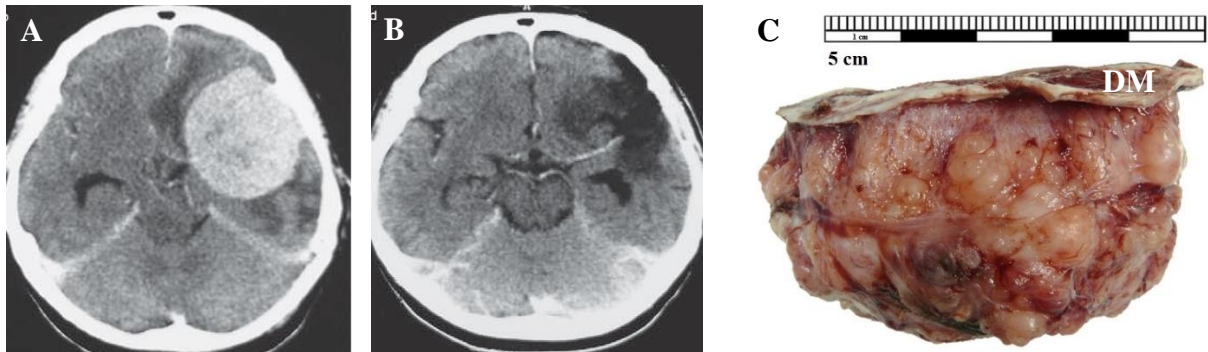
Pre-operative (A) and postoperative (B) CT scans show a left-sided meningioma-like contrast-enhancing tumor, originating at the left sphenoid wing. Postoperative CT scan 1 year after surgery shows that the tumor was completely removed and does not recur (images kindly provided by Dr. Vladimir Balik). Completely resected meningioma with attached dura mater (DM; C) adapted from Shivapathasundram’s review article [4].
